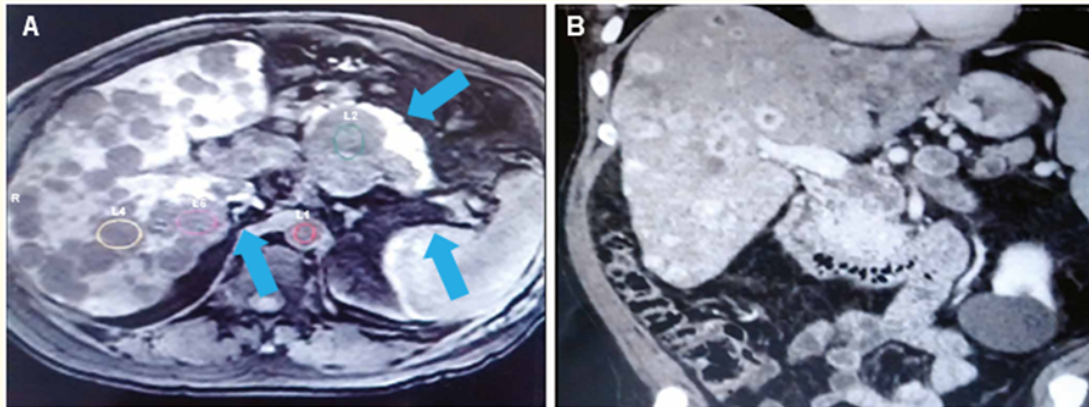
MRI: A) A compromise of the pancreatic cephalic portion and multiple liver lesions is observed. B) A thrombosis of the splenoportal axis can be seen.
